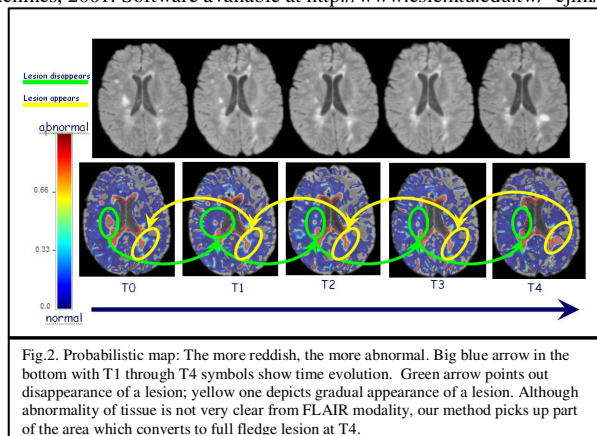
Probabilistic map: The more reddish, the more abnormal. Big blue arrow in the bottom with T1 through T4 symbols show time evolution. Green arrow points out disappearance of a lesion; yellow one depicts gradual appearance of a lesion. Although abnormality of tissue is not very clear from FLAIR modality, our method picks up part of the area which converts to full fledged lesion at T4.
